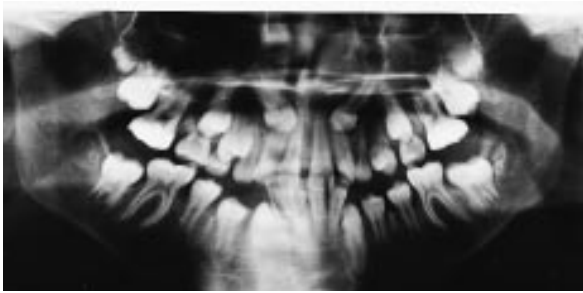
(a,b) Case 2 pretreatment radiographs.
